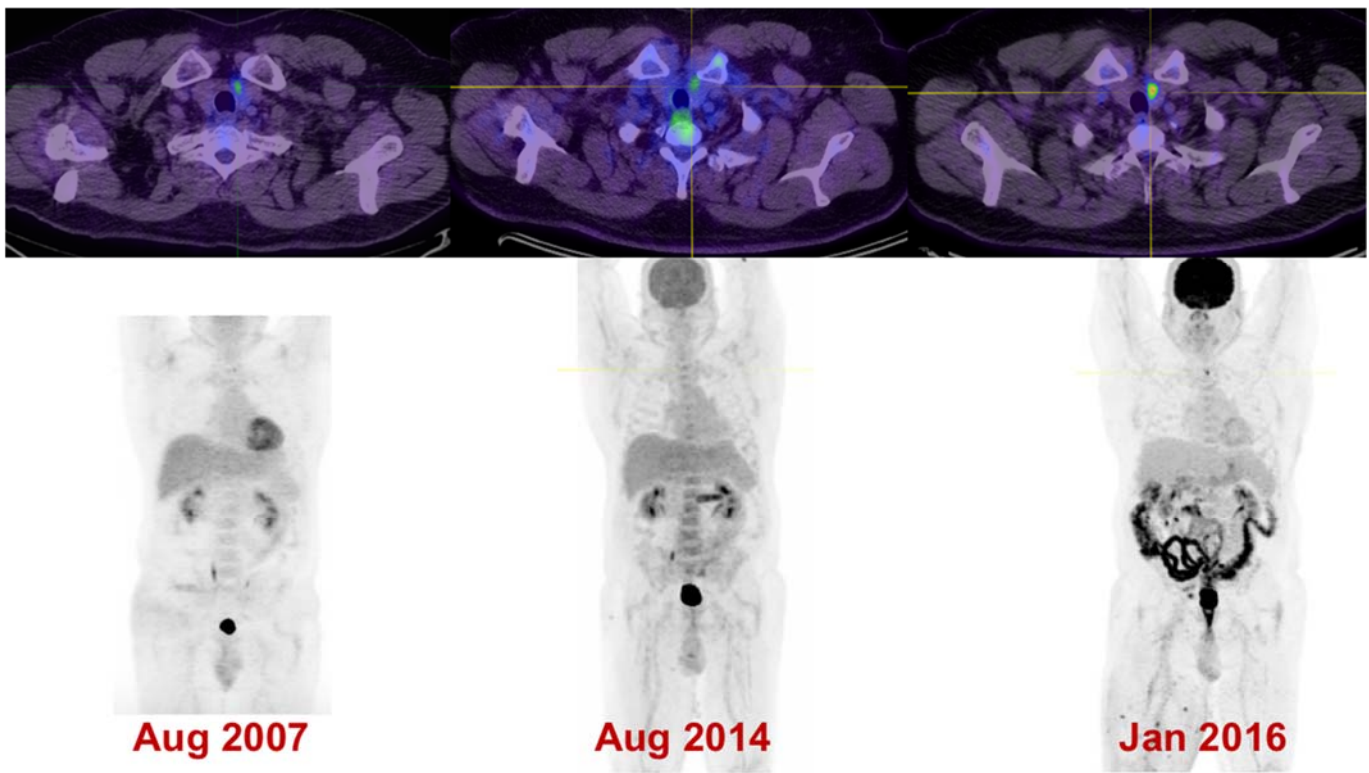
Mildly avid FDG-avid TI (SUVmax 3.1) was initially identified on staging FDG PET/CT of a 59-year-old man with metastatic melanoma in 2007. FNA (performed to exclude metastatic melanoma) confirmed an incidental papillary thyroid malignancy which remains stable under surveillance imaging and of limited clinical significance in the setting of metastatic melanoma under active treatment.
